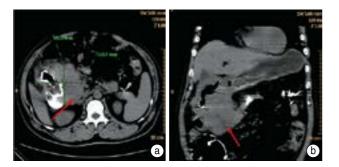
CT scan. (a) Inhomogeneous duodenal mass (sagittal section); (b) Duodenal tumor (transversal section)
